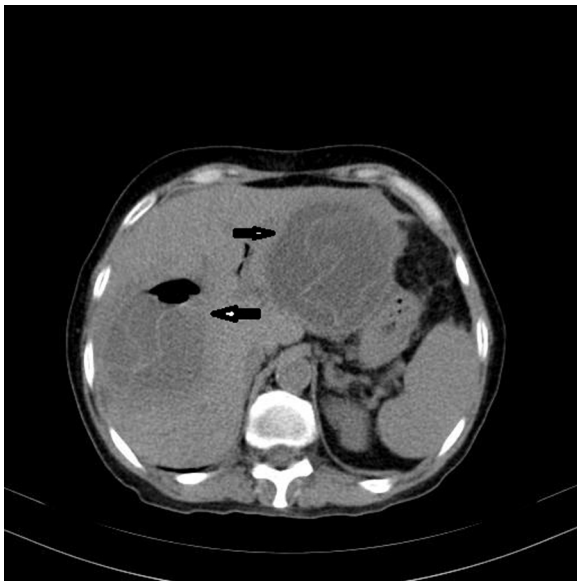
CT image showing the hydatid cyst that PAIR was performed.
